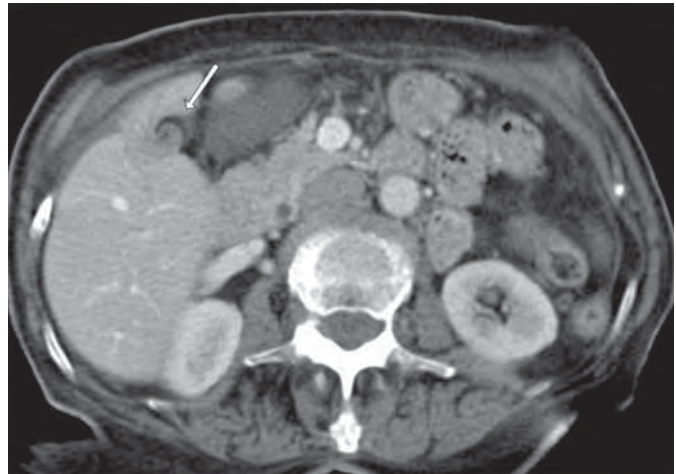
Axial CT slice demonstrating “whirl” sign suggesting volvulus.
